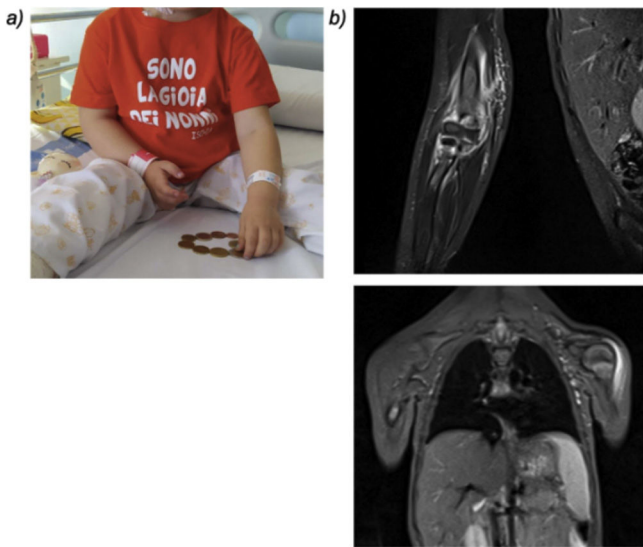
(a) Patient functional impairment and pain in the right elbow on day 5 of admission. (b) Whole body MRI images showing features compatible with fasciitis in the right arm, elbow and forearm and a focus of mild fasciitis in the left deltoid.
